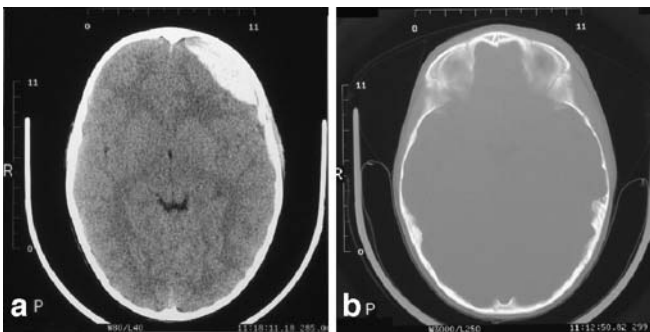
a CT on admission of a 6 4/12-year-old boy with fronto-basal epidural haematoma with complete compression of both lateral ventricles and a midline shift of 3 mm and b fracture of the orbital roof (patient number 2)
